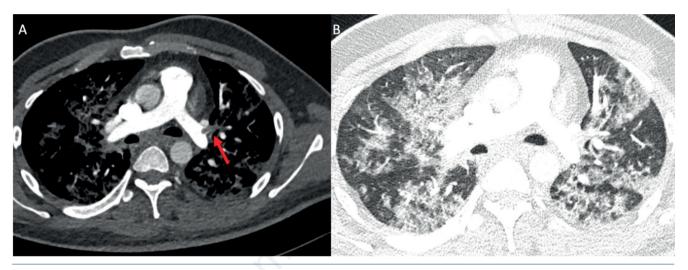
CT pulmonary angiography images. A) Axial image showing pulmonary thromboembolism in left pulmonary artery and its branches. B) Lung window showing bilateral ground glass opacities with interlobular septal thickening.
